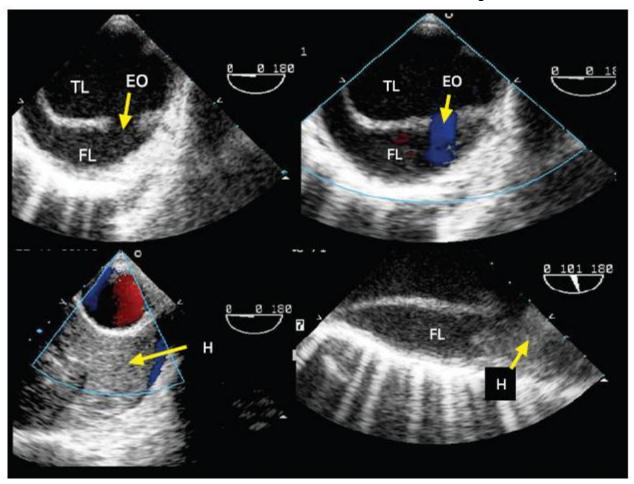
Transoesophageal echocardiographic examination obtained in a patient with acute aortic dissection. EO, entry orifice; FL, false lumen; H, intense spontaneous contrast + thrombus; TL, true lumen.
